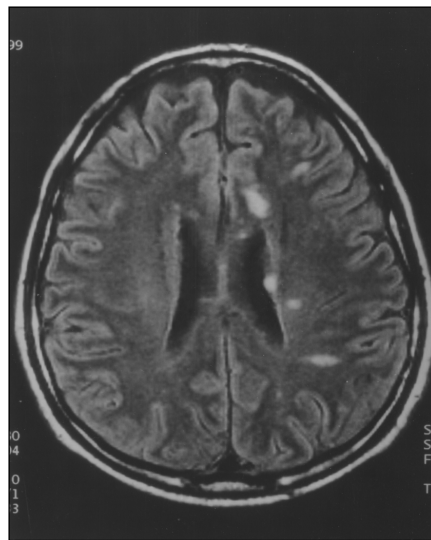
44-year-old man with acute Nipah encephalitis. Axial fluid attenuated inversion recovery MR image shows multiple discrete lesions in subcortical and deep white matter of cerebrum.
